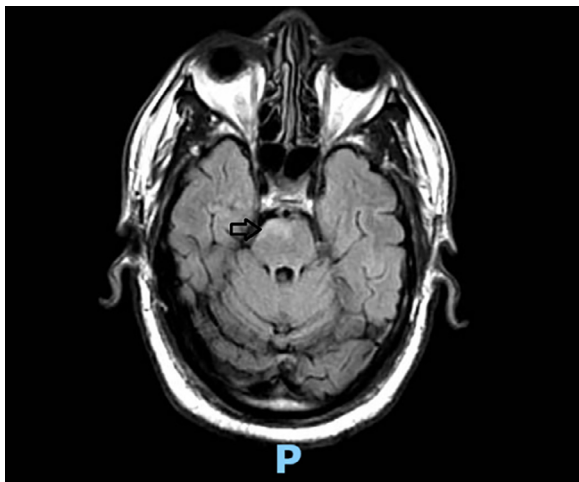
MRI of the brain without contrast. Right paramedian pons stroke with surrounding edema noted, (highlighted by black arrow).
